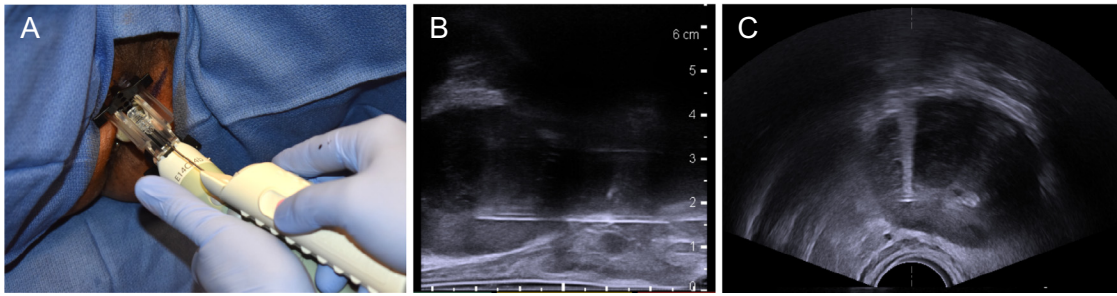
Biplanar ultrasound-guided biopsy of the prostate using the PrecisionPoint device. (A) Image of an 18 gauge biopsy needle being passed in-plane with the ultrasound probe through the access needle of the PrecisionPoint device. (B) Sagittal and (C) axial ultrasound images of the biopsy needle within the right posterior medial sector of the prostate. (Color version available online.)
